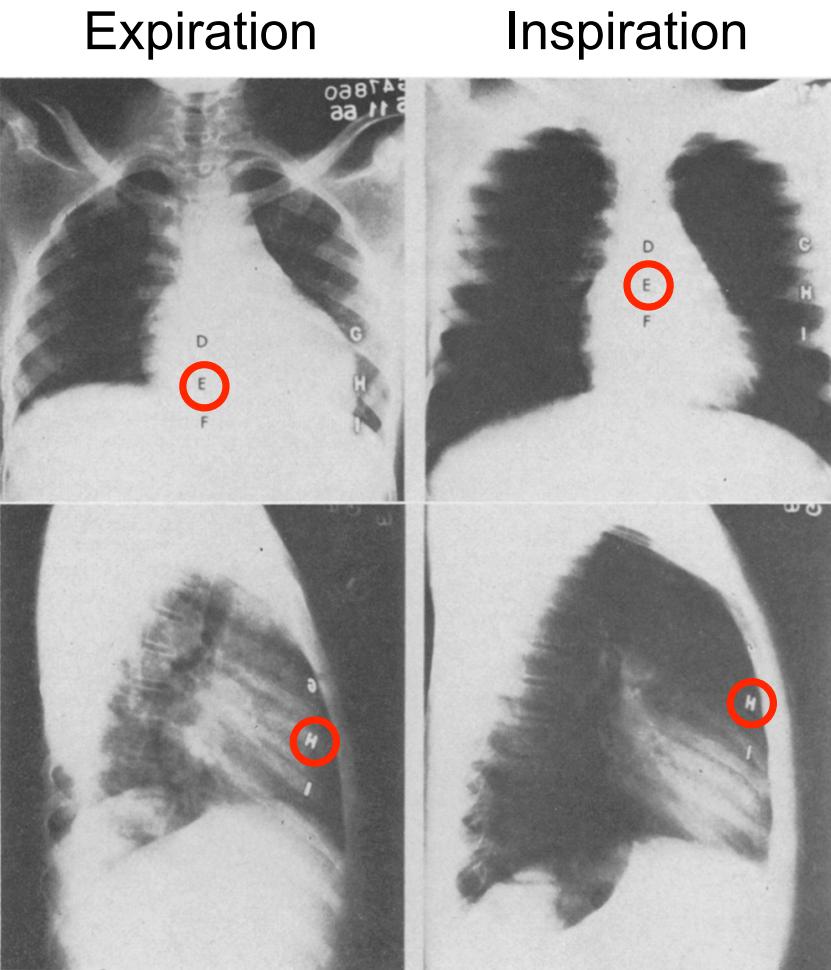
X-ray during expiration and inspiration with marked ribs - Adapted from [14]
